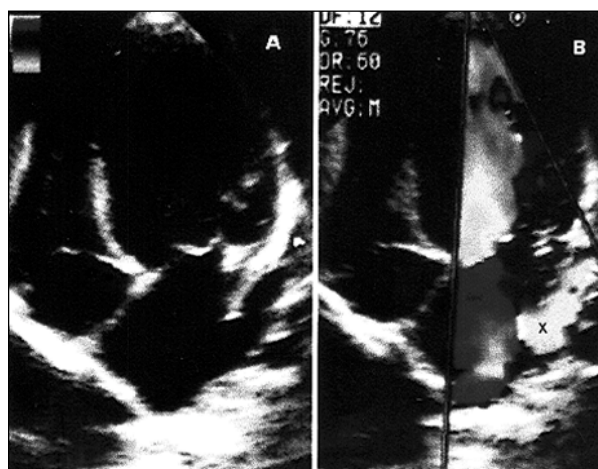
Two-dimensional echocardiographic data obtained in apical 4-chamber view: A) dilated left inferior pulmonary vein visualized close to the left atrial appendage; B) color-flow mapping showing laminar flow inside the left inferior pulmonary vein (x) draining into the left atrium.
